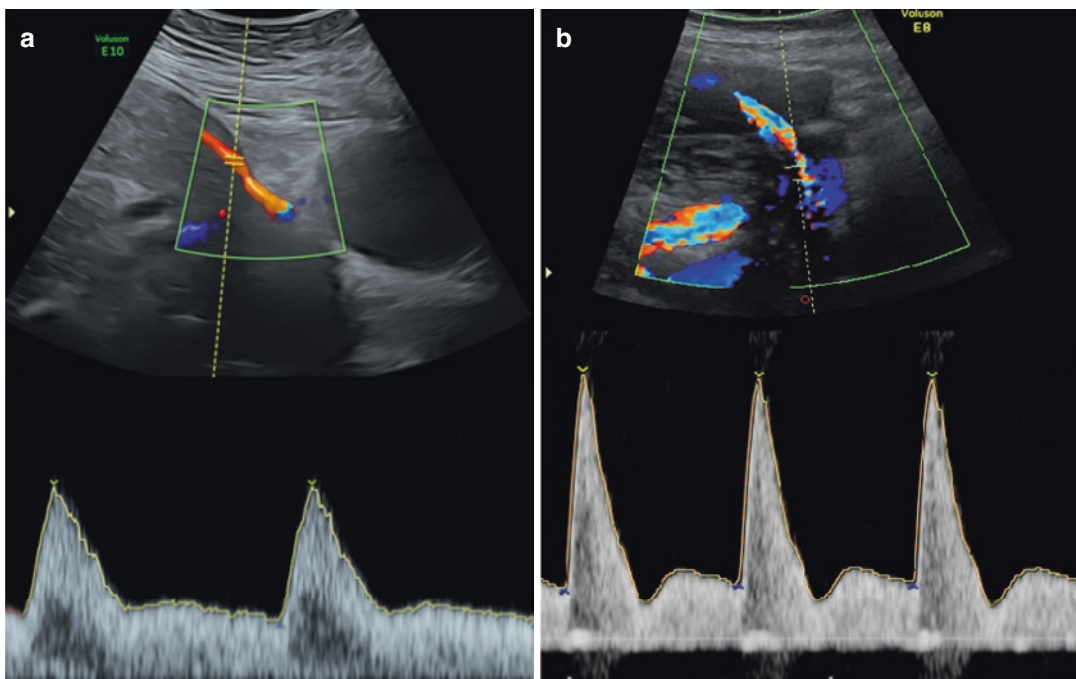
Second-trimester uterine artery Doppler waveform: (a) left, normal waveform: no notch and good diastolic flow and (b) right, early diastolic notch with restricted diastolic flow
